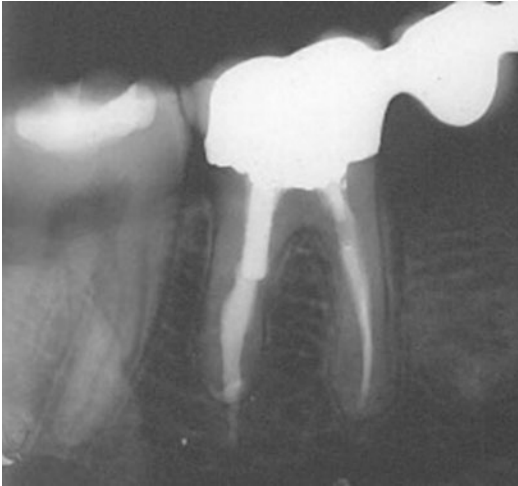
Post-mortem periapical radiograph to be compared with ante-mortem images in Fig. 8.1: even if two different techniques are used (OPG and periapical) the post-mortem radiograph shows the first right lower molar with the same projection of the ante-mortem one
